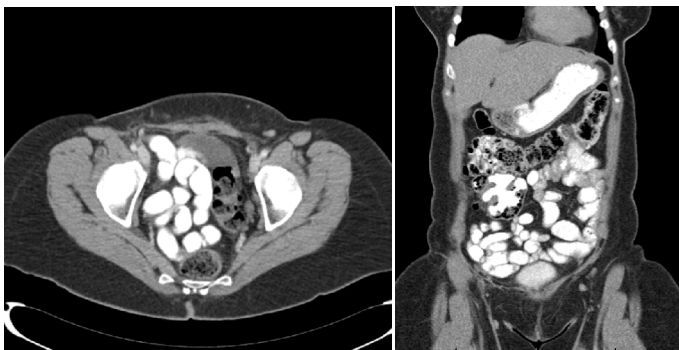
Most recent imaging as of July 2020 with transverse (left) and coronal (right) MRI images demonstrating no evidence of suspicious masses or lymphadenopathy in the chest, abdomen or pelvis.
